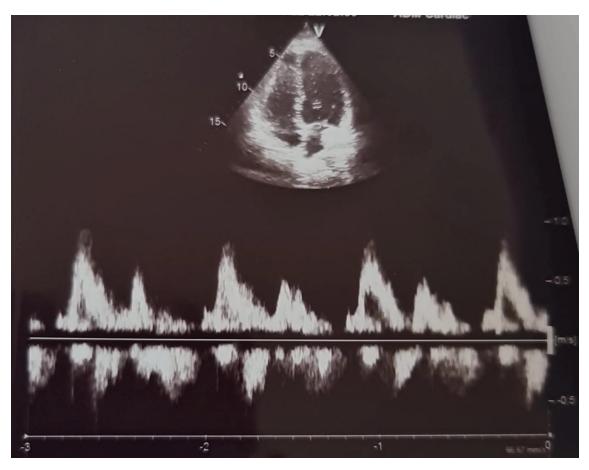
Preoperative normal echocardiography examination.
